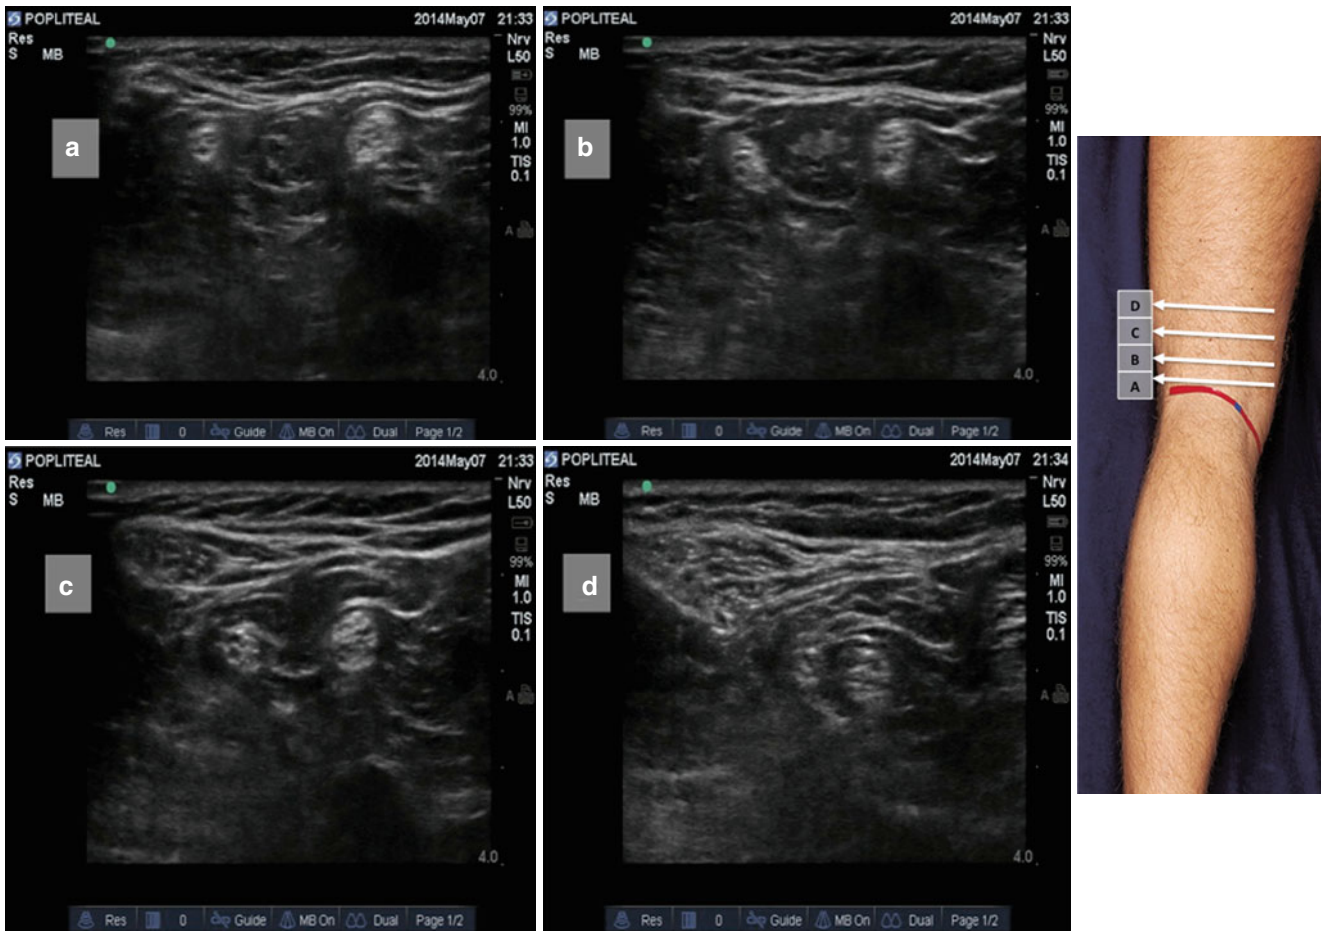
Scanning the sciatic nerve in the popliteal fossa from distal to proximal using the traceback method. The positions of the ultrasound in Figs. a to d correspond to the positions indicated in the figure on the right side. The tibial nerve (nerve on the *right side*) and common peroneal
